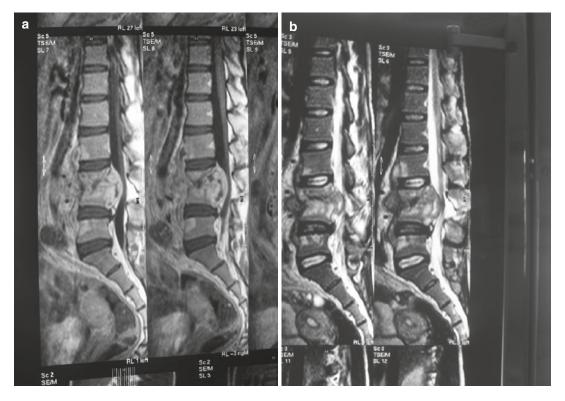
T1-weighted (a) and T2-weighted (b) sagittal MRIs showing an abscess within the spinal canal in the same patient as in Fig. 15.5 (Courtesy of P. Fernandes, M.D.)
